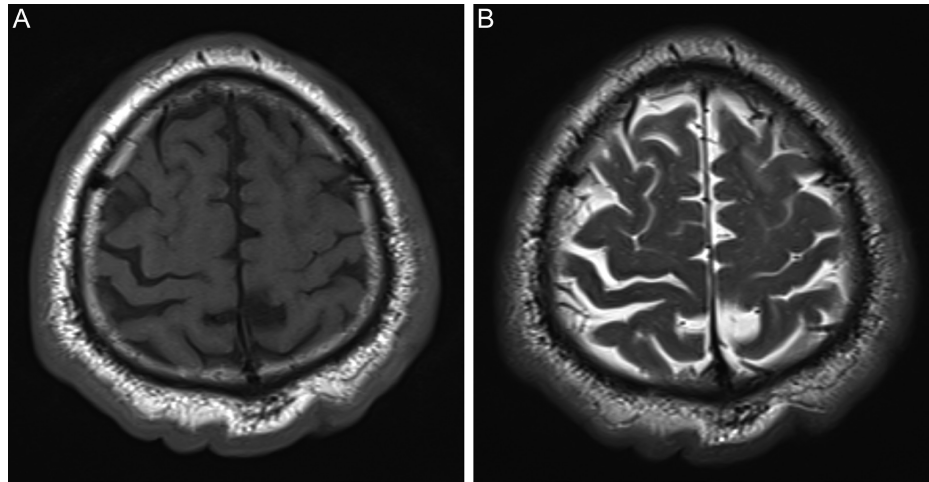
Axial T1- and T2-weighted magnetic resonance images show mild and asymmetric cutis verticis gyrata morphologies.
